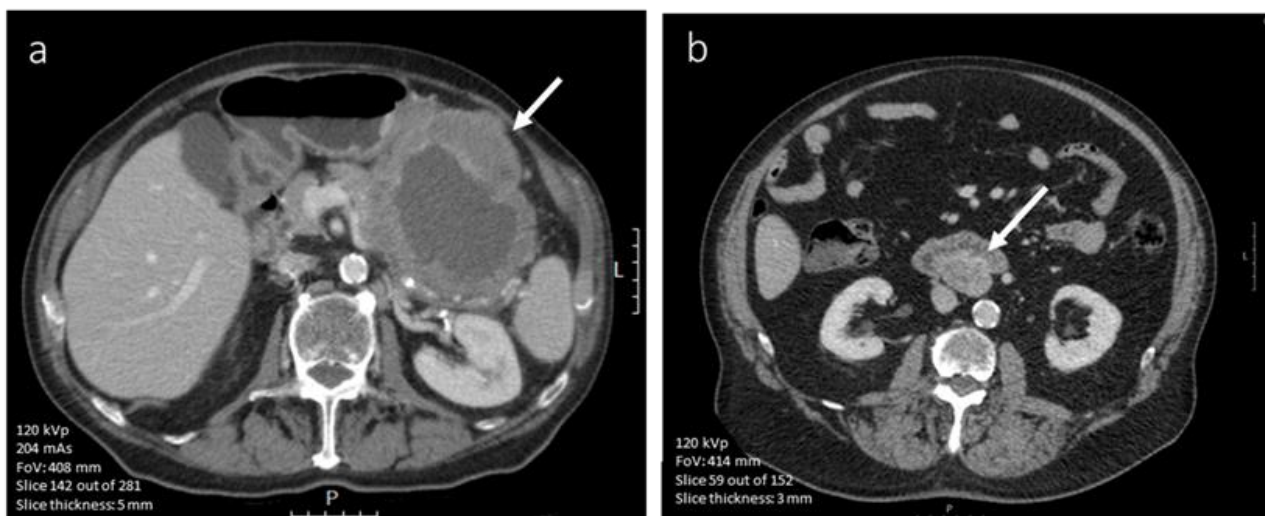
(a-b) Axial portal venous phase (iodinated contrast media) CT image of an 83-year-old male diagnosed with a high-risk (Miettinen AFIP classification) gastric GIST (scale bar 5 cm). The large lesion is lobulated and has central necrosis (arrow). (b) Axial portal venous phase (iodinated contrast media) CT slice of a 72-year-old male diagnosed with a low-risk GIST affecting the small intestine (scale bar 5 cm). It shows a well-defined and rounded lesion with a homogeneous enhancement pattern (arrow).
